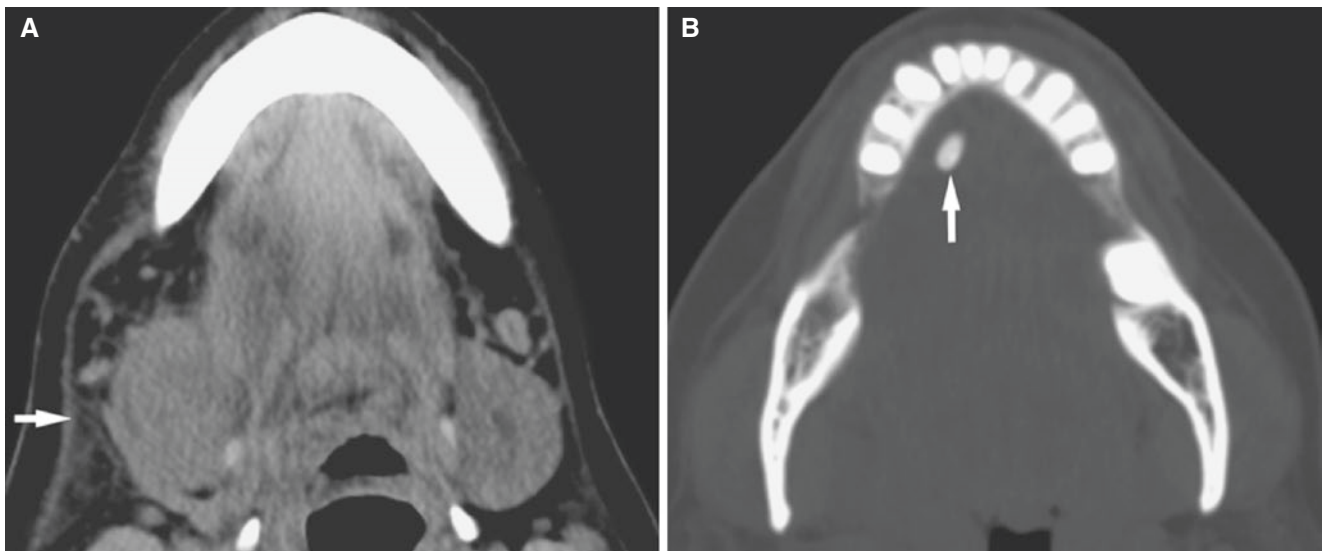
Submandibular sialoadenitis due to stone in distal duct; 59-year-old female with right submandibular swelling. (A) Axial post-contrast CT image shows enlarged submandibular gland with stranding
